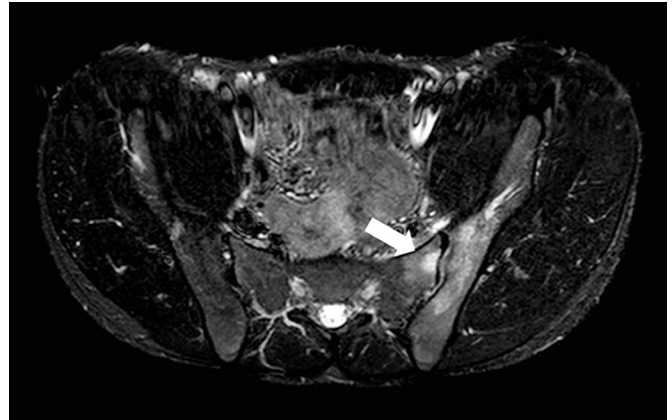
T1-weighted magnetic resonance image in a patient with juvenile spondyloarthritis showing active inflammation in the left sacroiliac joint (arrow). Adapted from the personal collection of the authors.
